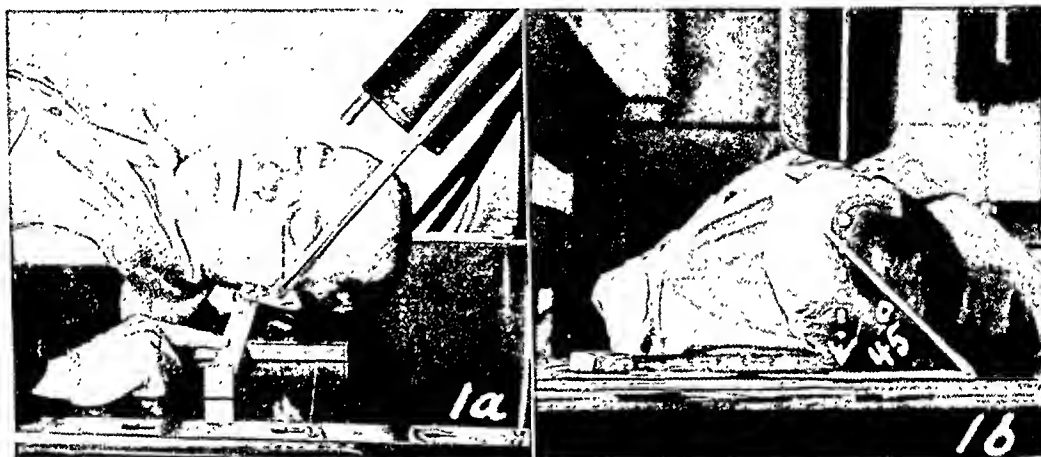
Positioning to obtain axial projection of the petrous bone. Note the 45-degree caudal angulation of the x-ray tube, the direction of the central ray through the external auditory meatus, and the 45-degree lateral rotation of the patient's head. The technician's finger points to the yardstick for measuring the distance from the mastoid tip to the edge of the cassette. Use of this measured distance for exact centering to the mastoid tip is demonstrated in Figure 1b.
